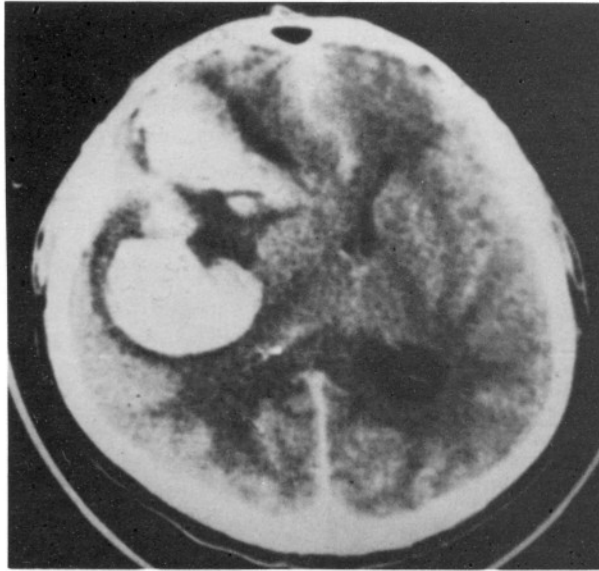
Preoperative CT of the case showing a right-sided frontoparieto-temporal haematoma following thrombolytic therapy for acute MI.
